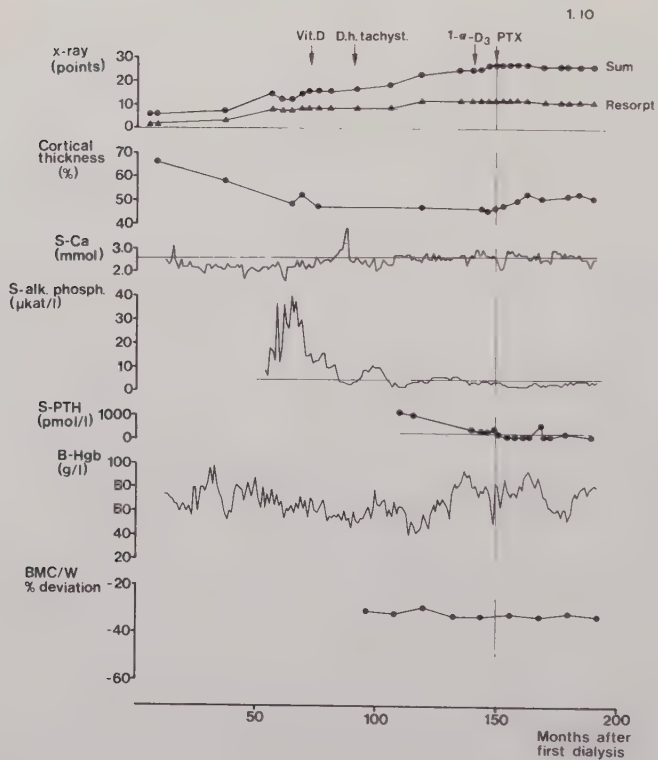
Some characteristics in X-ray, laboratory tests and densitometry in one patient (IO) followed for 16 years on RDT.
